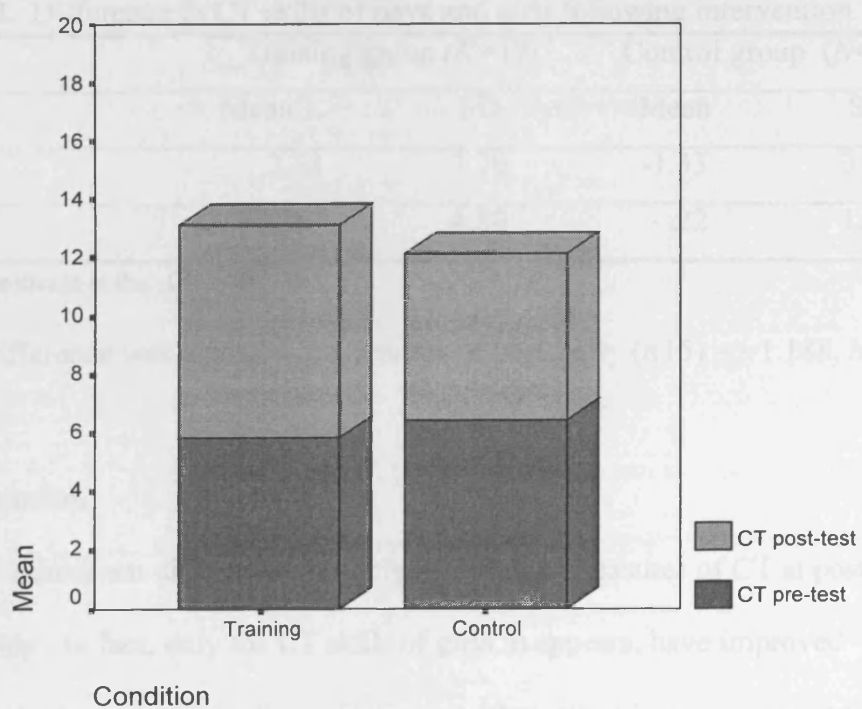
PROGRESS IN CT SKILLS FOLLOWING INTERVENTION.
